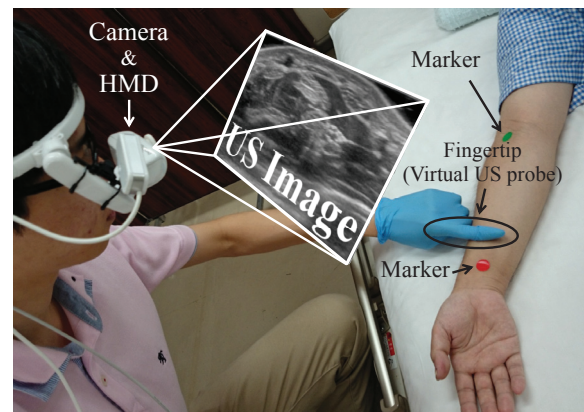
Concept of the virtual ultrasonic probe system.
